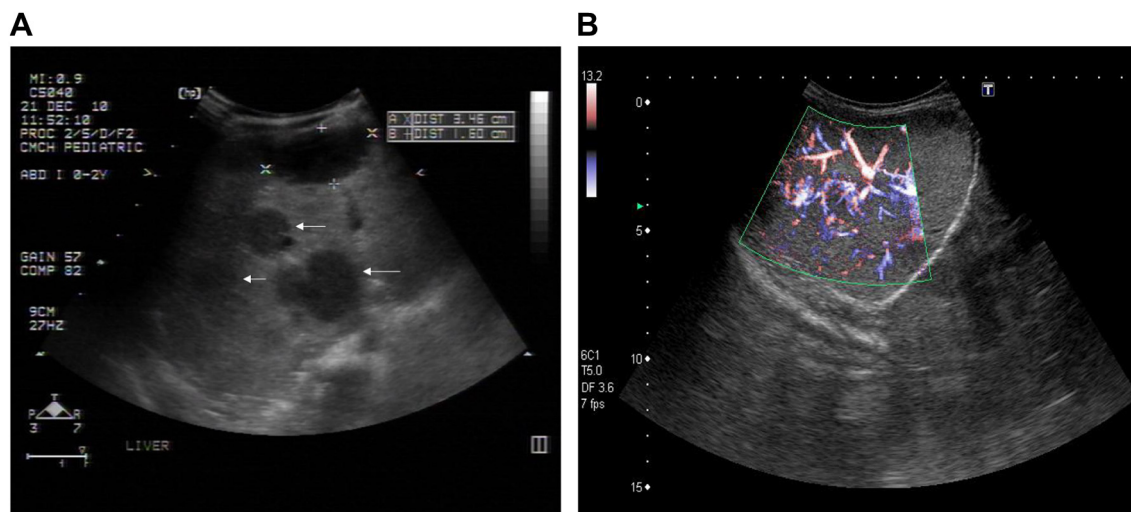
(A) Abdominal sonography revealed multiple hypoechoic masses (white arrows) throughout the liver parenchyma. (B) Blood flow without shunting in the masses was noted on Doppler examination.
